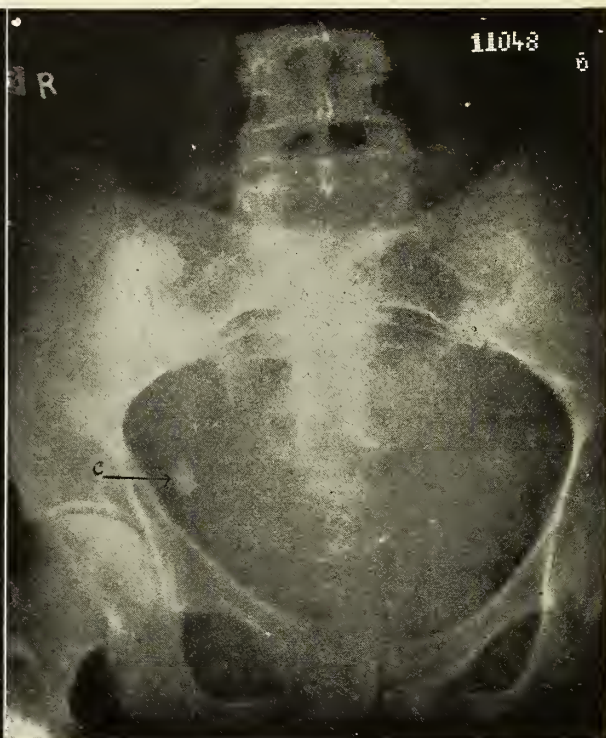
Case 3. X-ray showing calculus.
